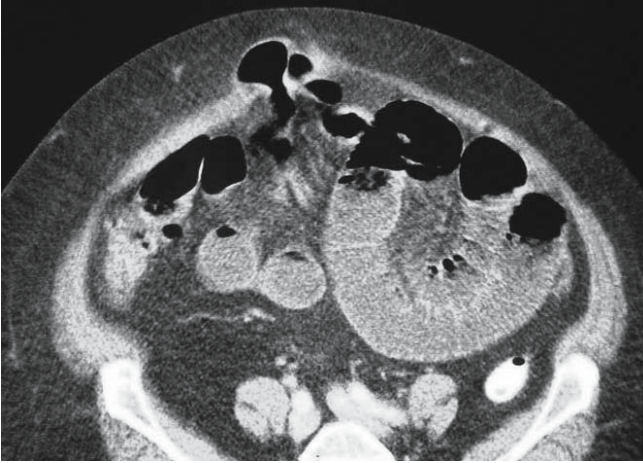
Abdominal CT: incisional hernia. Note a loop of small bowel incarcerated within an incisional abdominal wall defect
